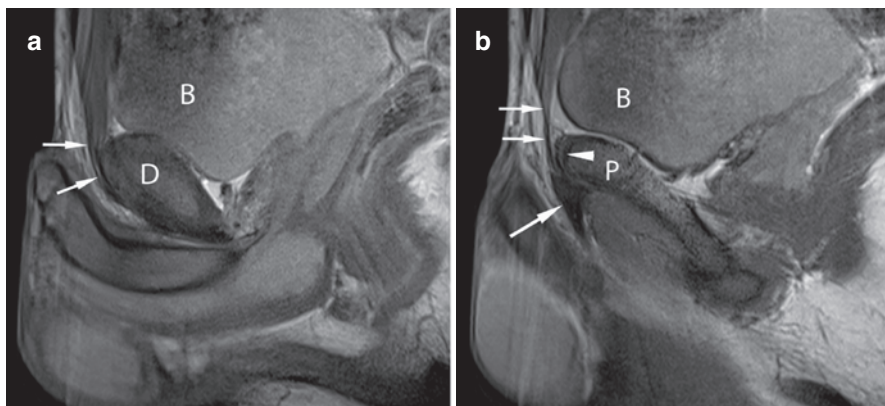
(a) Sagittal T1w MR images show the bladder (B) posteriorly, the rectus abdominis/pyrimidalis tendons (*arrows*) merging with anterior symphysis capsule and disc (D). (b) Lateral to a shows the pubic body (P) with the rectus abdominis tendon (*arrows*) and adductor longus tendon (*large arrow*) merging anteriorly
